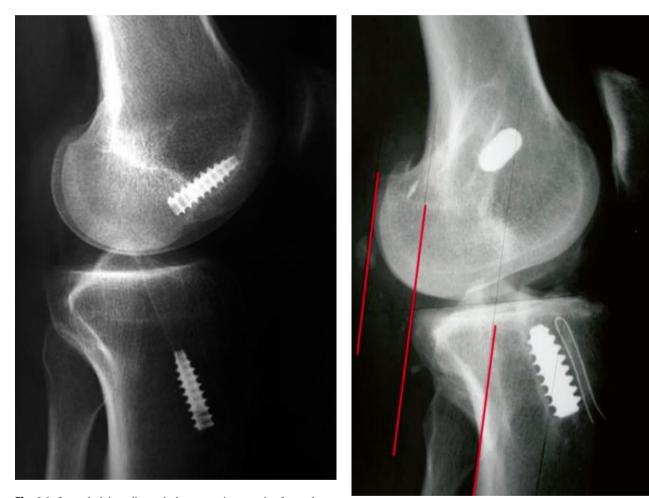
Lateral plain radiograph demonstrating anterior femoral tunnel malposition
